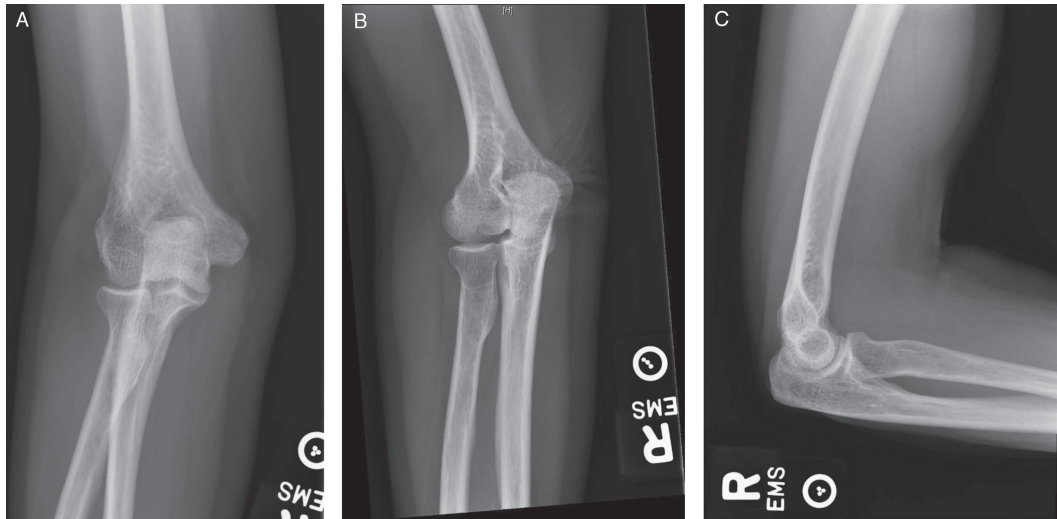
Anteroposterior, oblique, and lateral radiographs of the right elbow—Subtle mineralization about the triceps insertion is noted. Otherwise normal radiographs.
